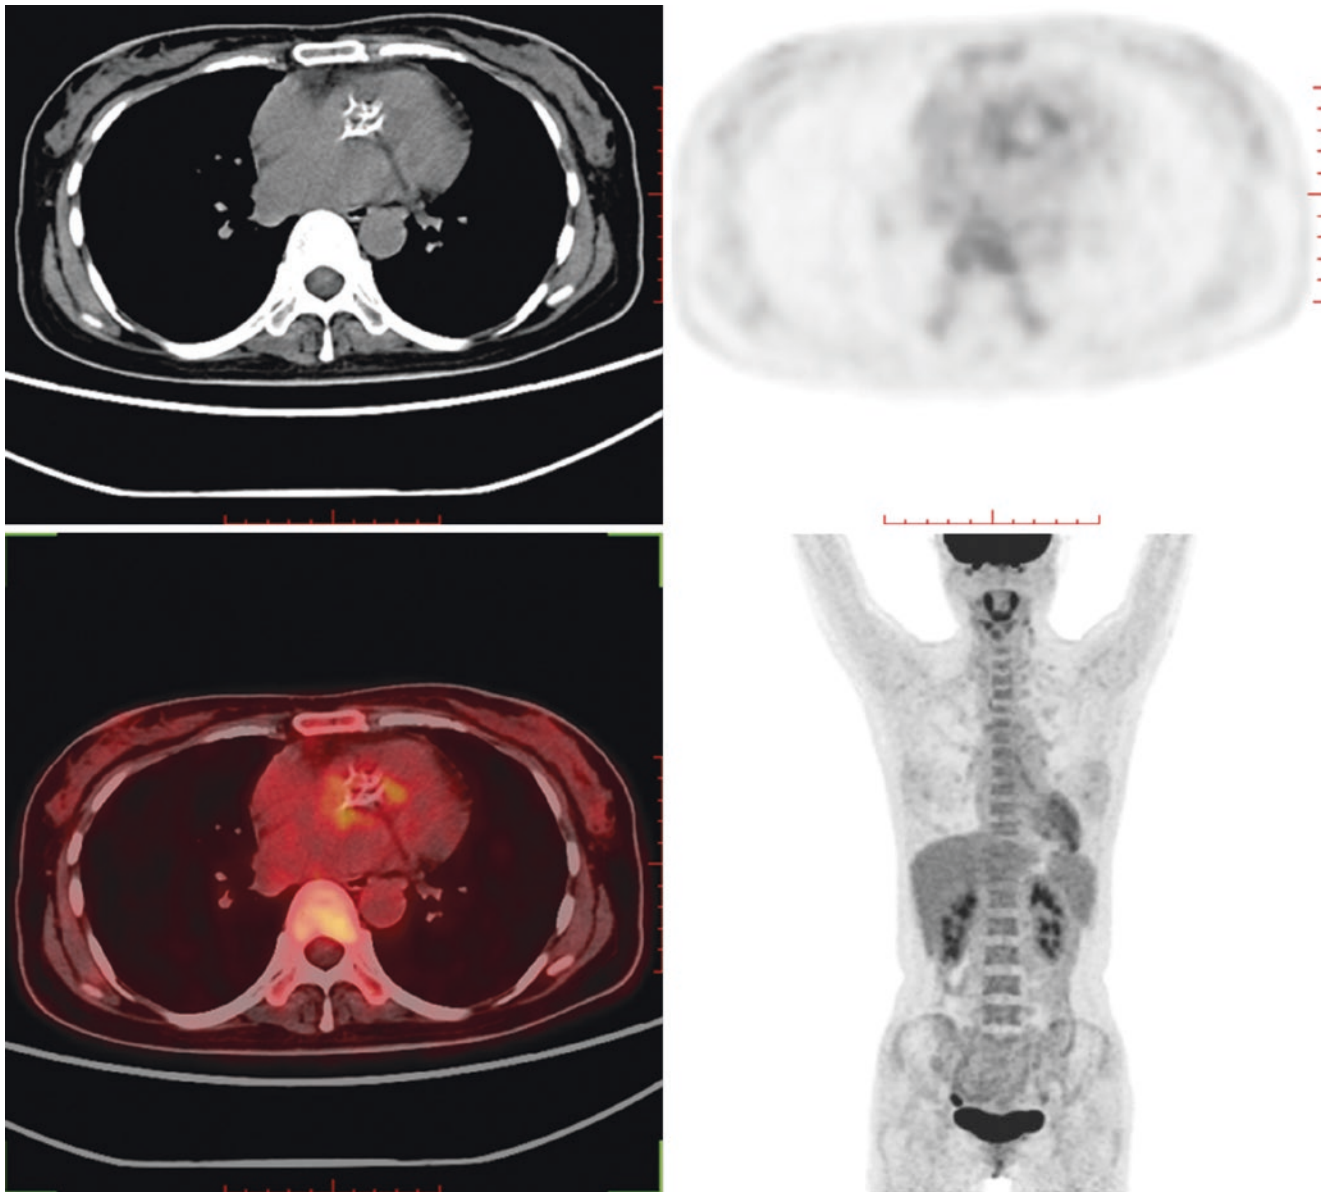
Images demonstrate notable calcification of aortic valve on CT and mild increased FDG uptake of soft tissue around the calcified foci on the fusion image ($SUV_{max} = 3.1$)
